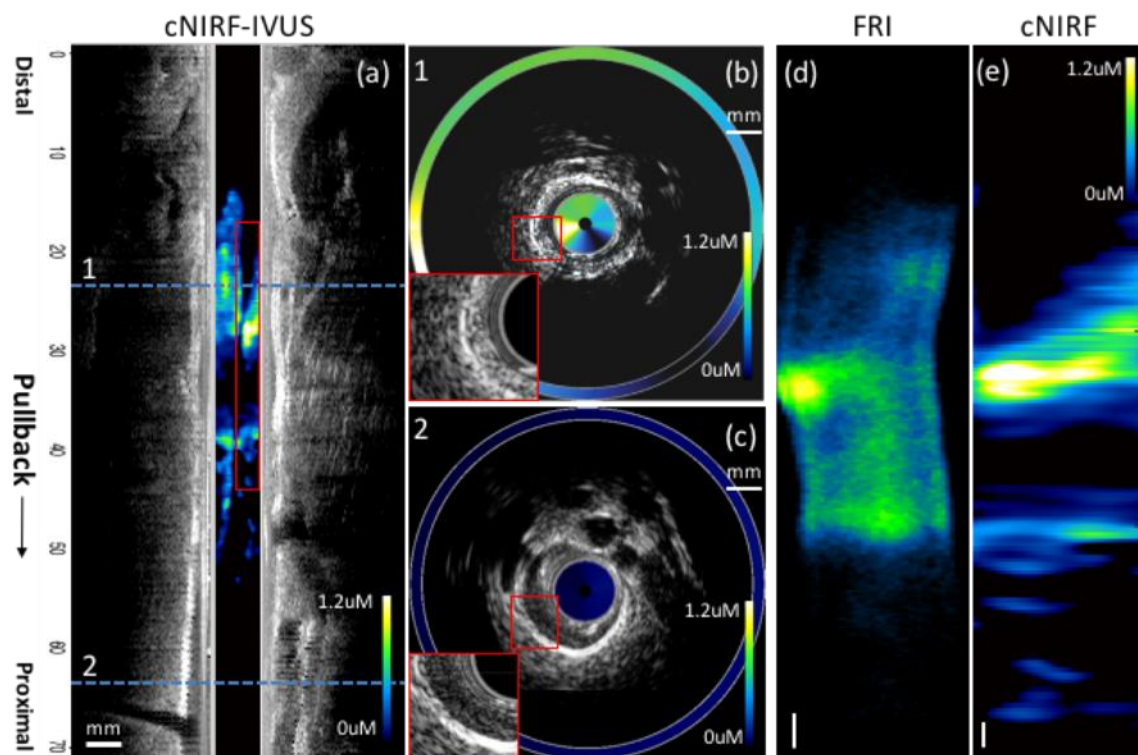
In vivo cNIRF-IVUS imaging of atherosclerosis. Fused longitudinal ultrasound (black and white) and cNIRF images of the rabbit atheroma. Representative cNIRF-IVUS cross-sectional images in the pullback position 1 and 2 are shown in (b) and (c), with lower left magnified insets demonstrating evidence of atherosclerosis at position 1 in (b). The ex vivo fluorescence reflectance image (FRI) of the resected artery (d) correlated with the cNIRF image (e). Scale bars, 1 mm for all images.
